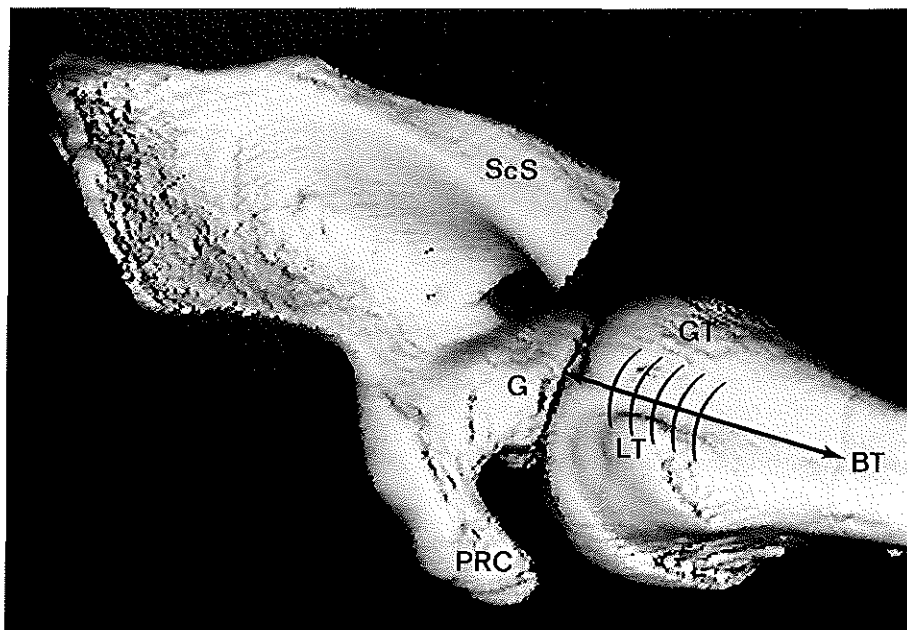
Three-dimensional CT-reconstruction of a superior view on the left GHJ when the arm of this healthy volunteer was held in the maximally elevated position. The humerus was free to rotate about its longitudinal axis. Greater and lesser tuberosities are in the vicinity of the biceps tendon origin. Acromion has been (digitally) resected. Compare with figure 5.5. BT= course of the biceps tendon (indicated with long arrow); G=Glenoid; GT=greater tuberosity; LT=lesser tuberosity; ScS=scapular spine.
